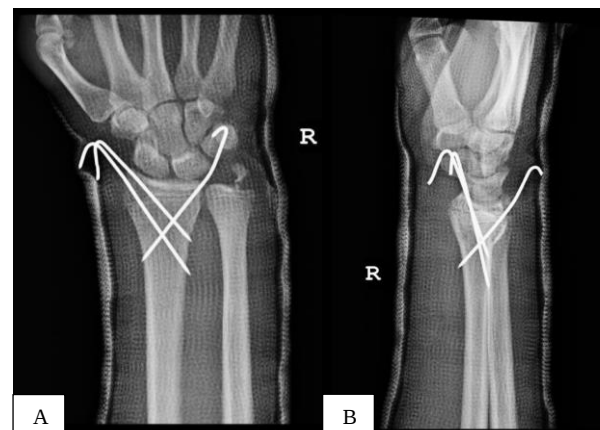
Postoperative anteroposterior (AP) (A) and lateral (B) radiographs
